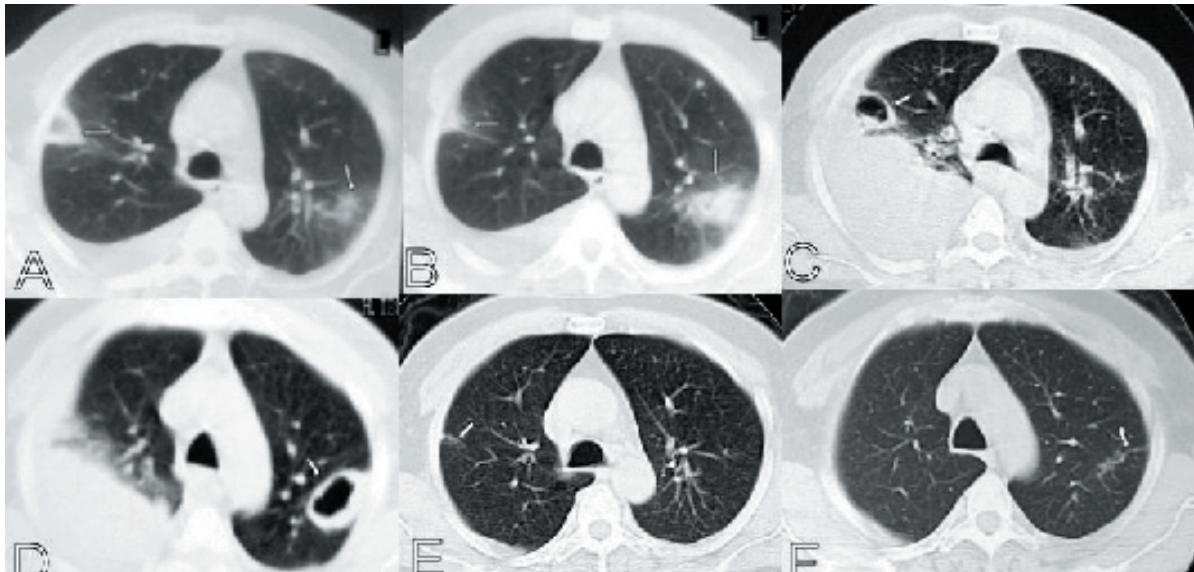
A, B. In thorax CT examination, well demarcated consolidations are seen in the posterior segment of right upper lobe and in the apicoposterior segment of left upper lobe. C, D. Two cavitary lesions and massive pleural effusion in the right and minimal in the left were detected at the fifth day of treatment. E, F. At the control CT of second month, no cavity or consolidation was detected, and right pleural effusion was completely disappeared. Only bilateral sequel changes can be seen.
